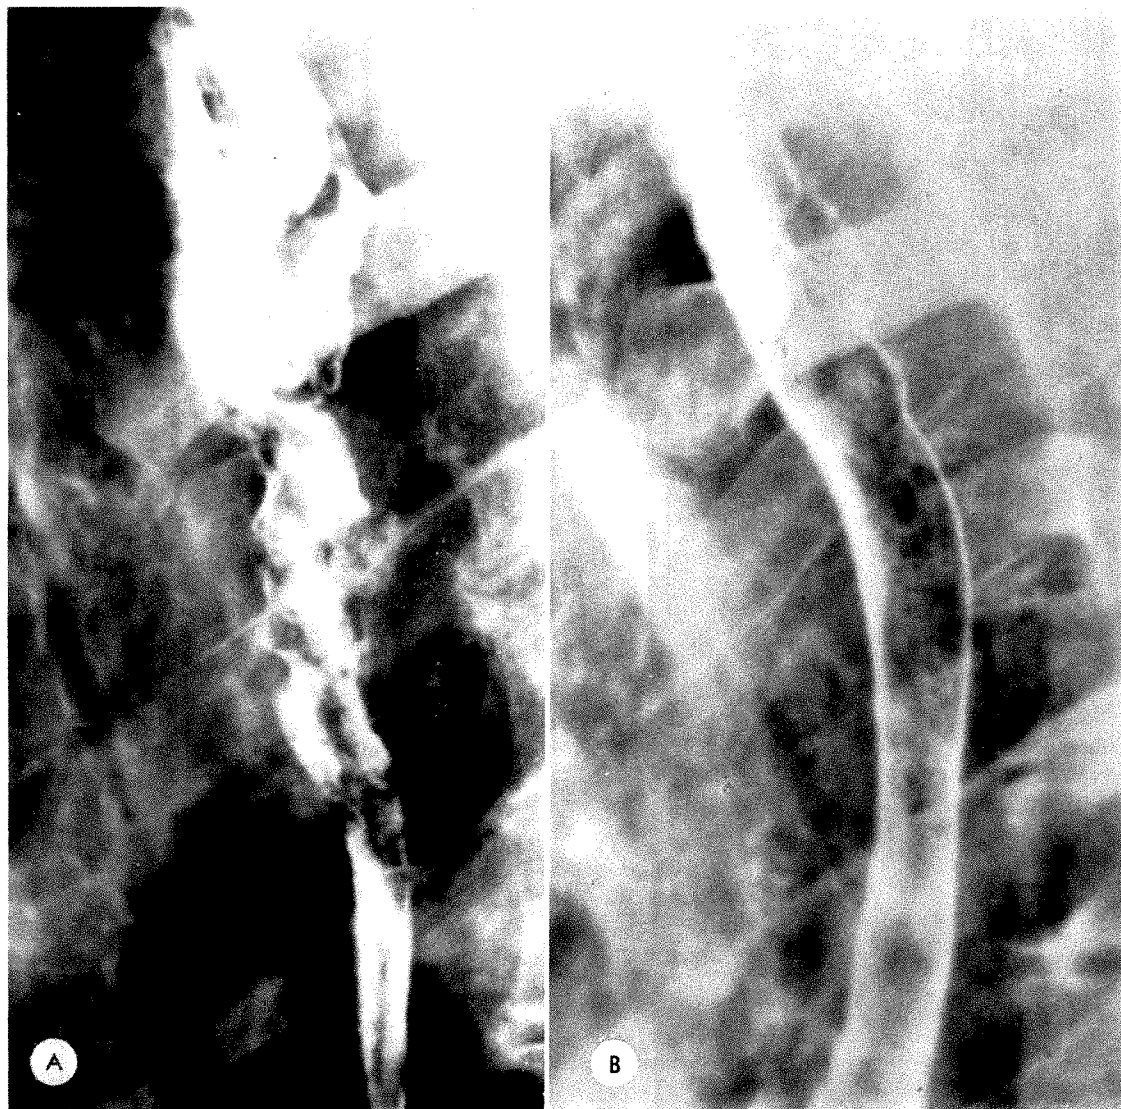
Case II. Carcinoma of esophagus. (A) Pretreatment roentgenogram showing ragged tumor involving upper one-third of esophagus. (B) Post-treatment roentgenogram. Note smooth open lumen.
